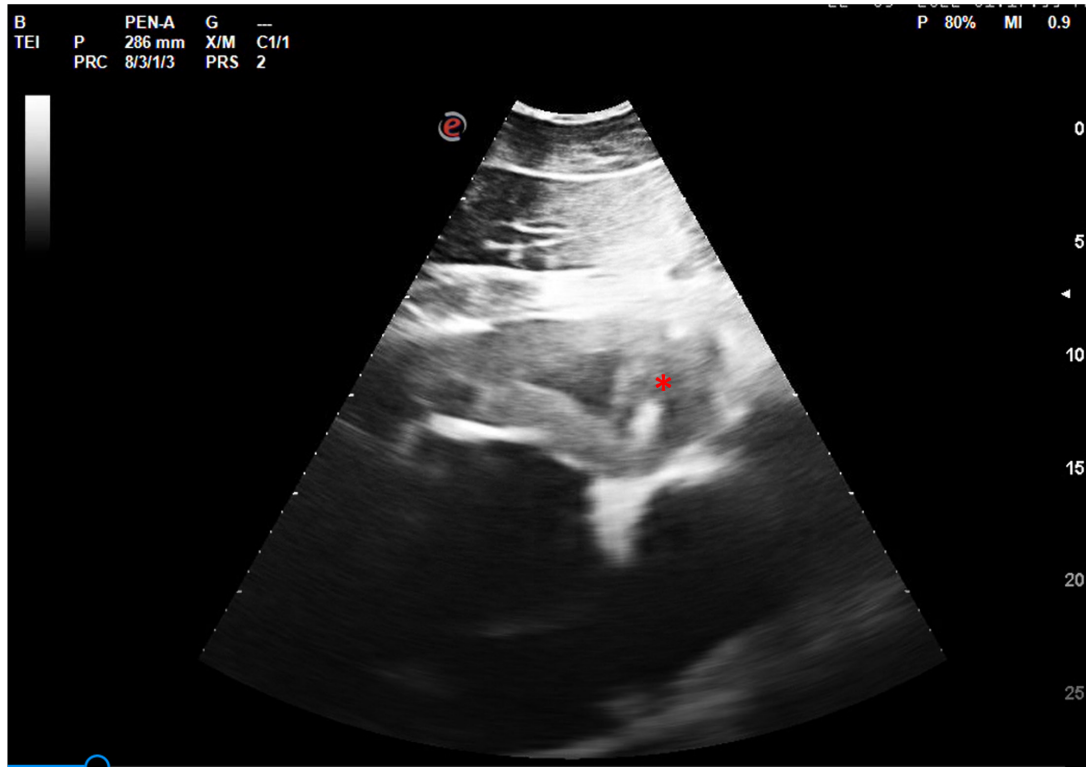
Ultrasound image of the heart showing irregular border and thickening of the left ventricle wall (*).
